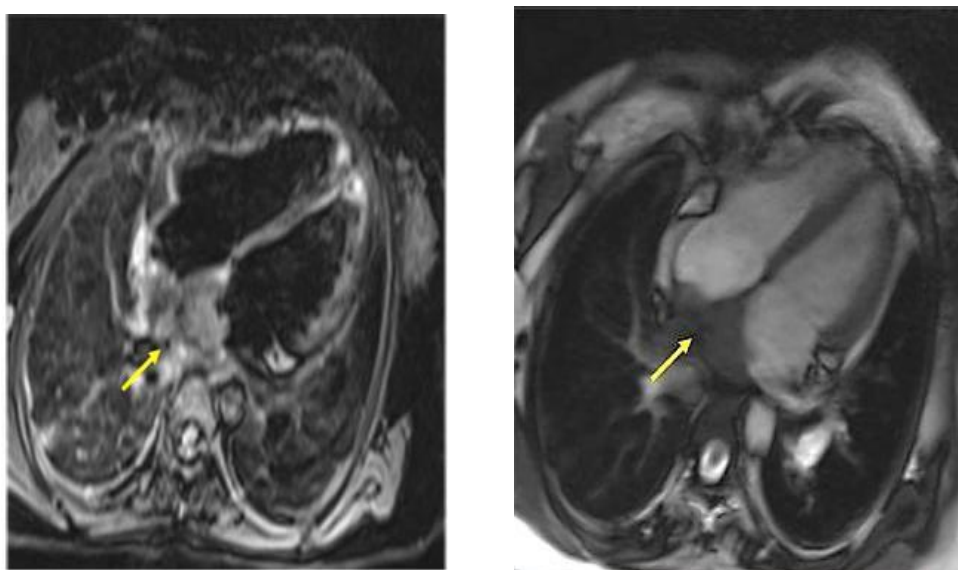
MRI of case of angiosarcoma showing Hypointense mass centred at interatrial septae extending to right & left atria
